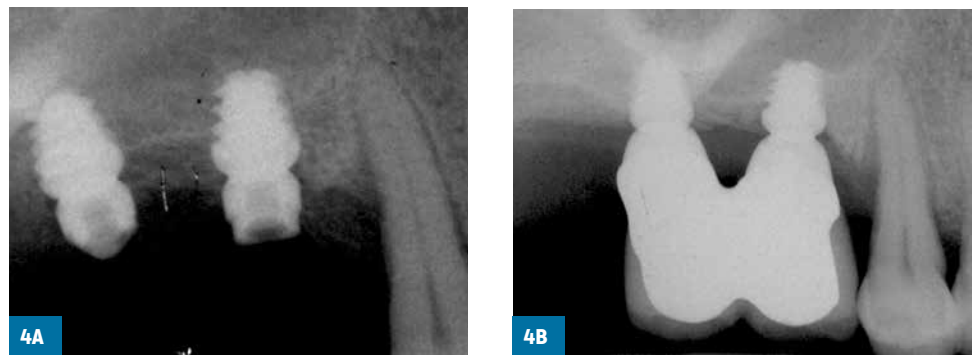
Treatment sequence of one of the patients randomly allocated to sinus lift and long implants: periapical radiographs just after implant placement (A) and 3 years after loading (B).
